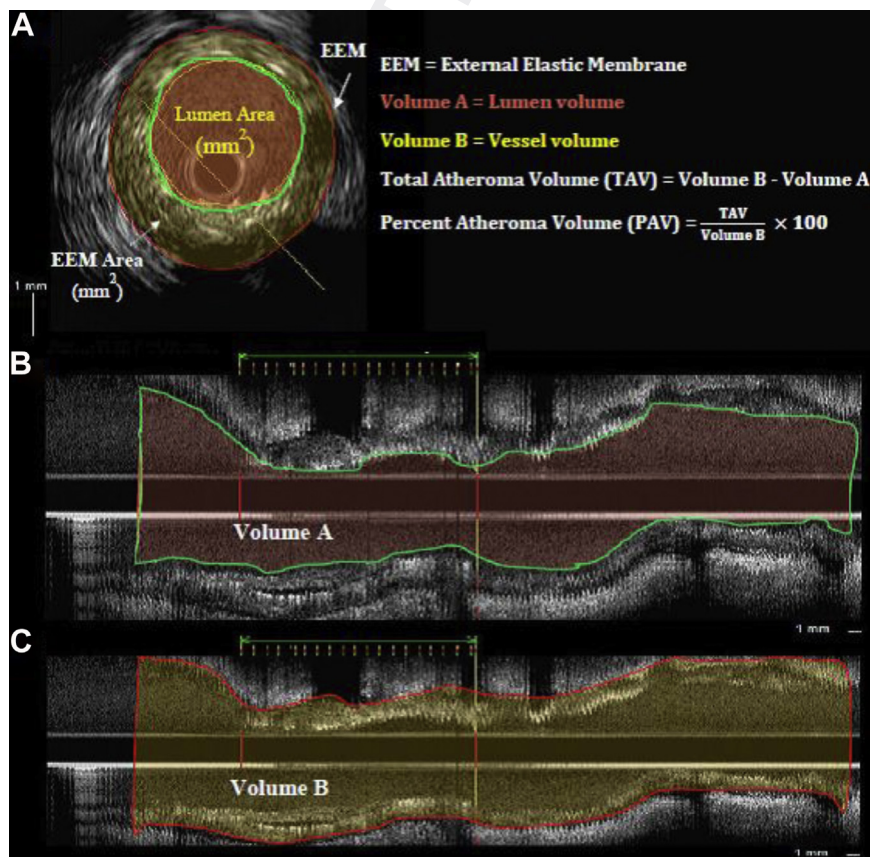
Intravascular ultrasound of coronary artery to assess plaque volume. (A) Planimetry of external elastic membrane (EEM) and lumen area; Formula to calculate TAV and PAV using lumen volume and vessel volume; (B) Longitudinal view of the same segment of coronary artery assessing lumen volume (Volume A); (C) Evaluation of vessel volume (Volume B). PAV, percent atheroma volume; TAV, total atheroma volume.
